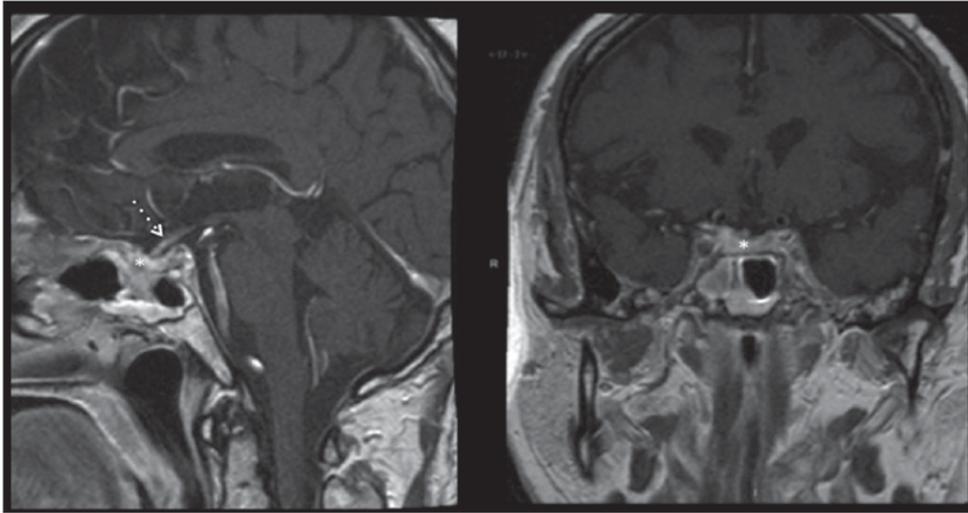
The postoperative cerebral magnetic resonance imaging with contrast confirms the complete resection of the lesion (sagittal view on the left panel and coronal view on the right panel). The lesion is no more present and the normal pituitary gland is visible (asterisk) in the sella. The pituitary stalk is well visualised in the sagittal plane (dotted arrow).
